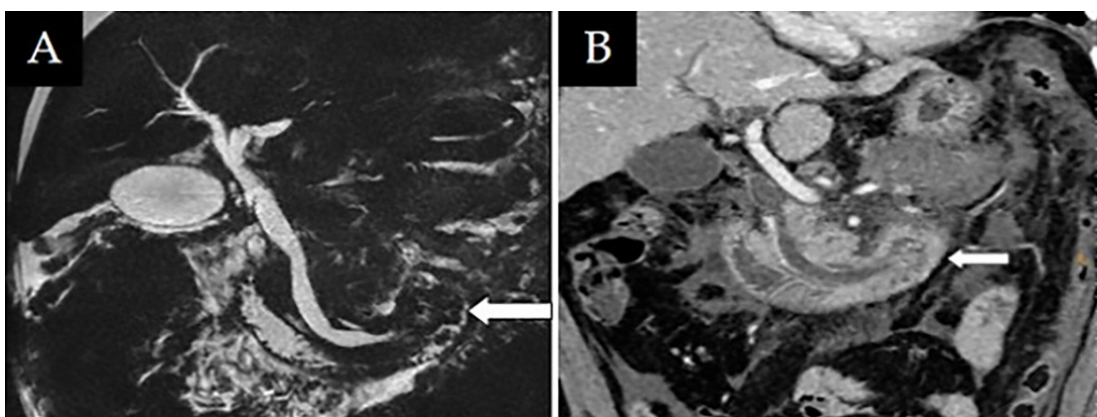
A, B - Radiological findings. A: Coronal reformatted MPR CT image showing a huge pedunculated polyp (arrow) within the second part of the duodenum. B: T2 weighted coronal MR image showing the relationship between the common bile duct and the head of the polyp (arrow).
